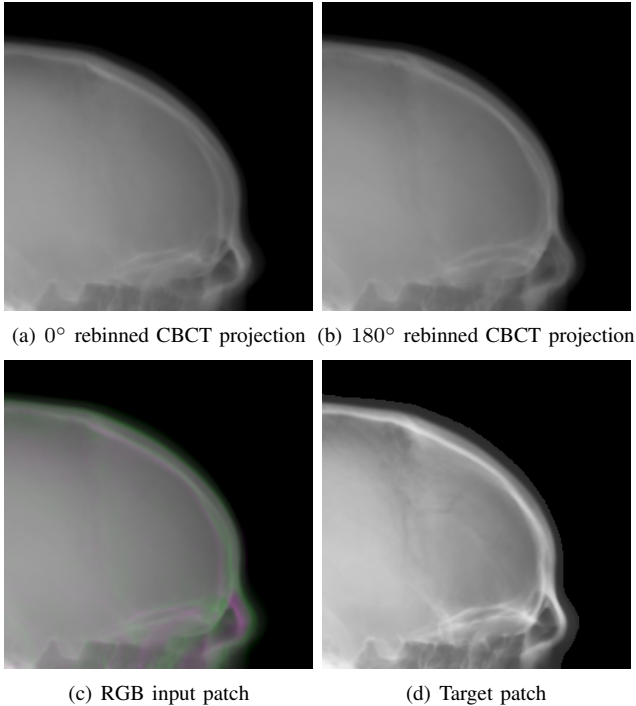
One patch example for dual projections to one cephalogram synthesis: (a) the first quadrant patch from the 0° cone-beam projection; (b) the first quadrant patch (horizontally flipped) from the 180° cone-beam projection; (c) the RGB patch using (a) for the red and blue channel and (b) for the green channels, where the colourful area highlight the difference between (a) and (b); (d) the target patch synthesized by our proposed volume-to-cephalogram method.
